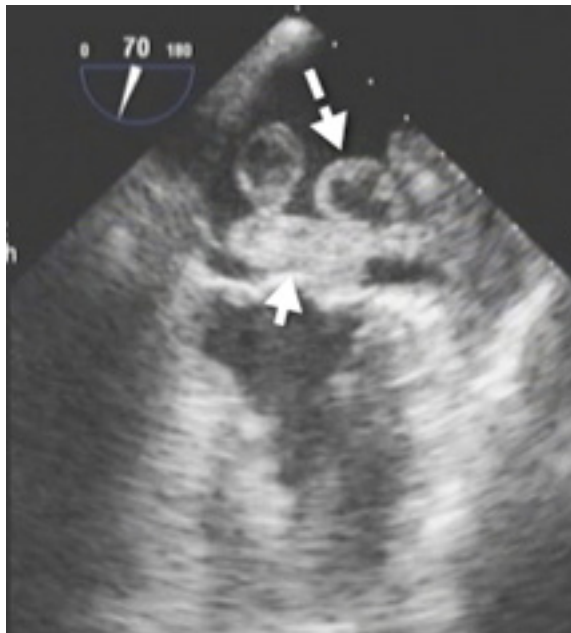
Transesophageal echocardiogram of a 68/F presenting with dizziness and dyspnea. There is note of two distinct masses within the left atrium- one is solid and the other one is cystic.
